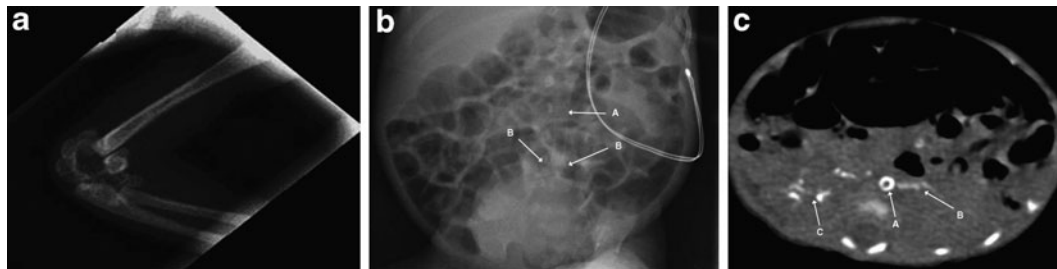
Radiographic manifestations of generalized arterial calcification of infancy. *Panel A:* X-ray scan of the patient's left elbow. Note the calcification of the elbow joint. *Panel B:* Abdominal X-ray of the patient at 20 days of life. Note the calcification of the abdominal aorta (A) and of the bifurcation of the iliac arteries (B). *Panel C:* Chest CT of the patient at the age of 2 months. Note a ring-like aortic calcification (A) and spread calcifications over the left lobe of the liver (B) and in the right kidney (C)
